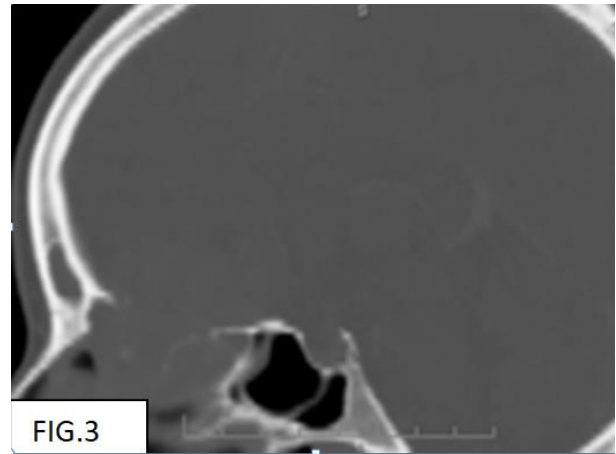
Sag CT (bone window): bone lysis.
